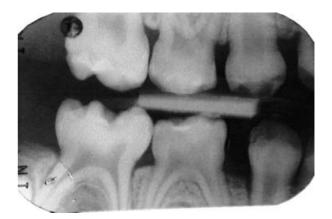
Right-hand-side bitewing radiograph.
